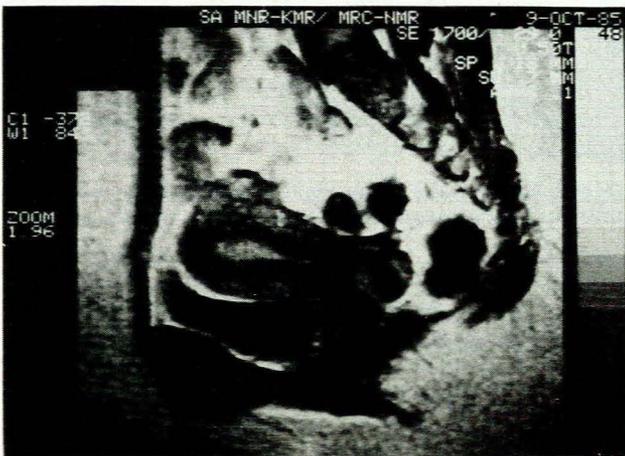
Anatomical features of the female pelvis clearly demonstrated by MRI (SE 700/29). Fibroids in the posterosuperior fundus can be identified clearly.
